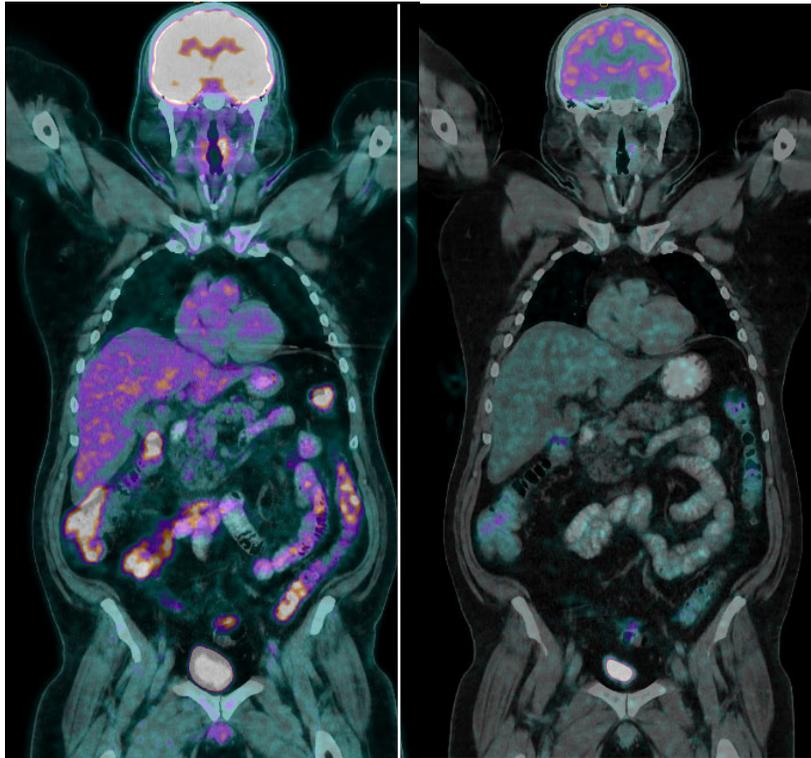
The repeated ^{18}F FDG PET/CT (left) demonstrating superior counts and quality compared to the original (right) suffering count loss associated with leaked activity.
